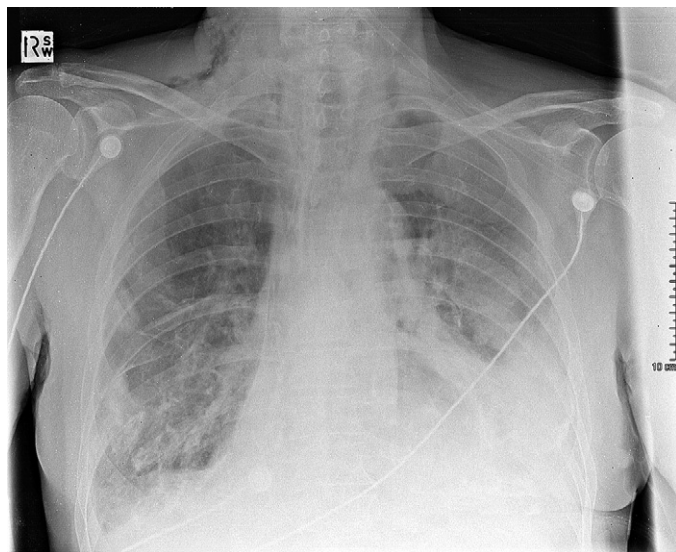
Anteroposterior chest radiograph showing pleural effusion, pneumomediastinum, and subcutaneous emphysema.
